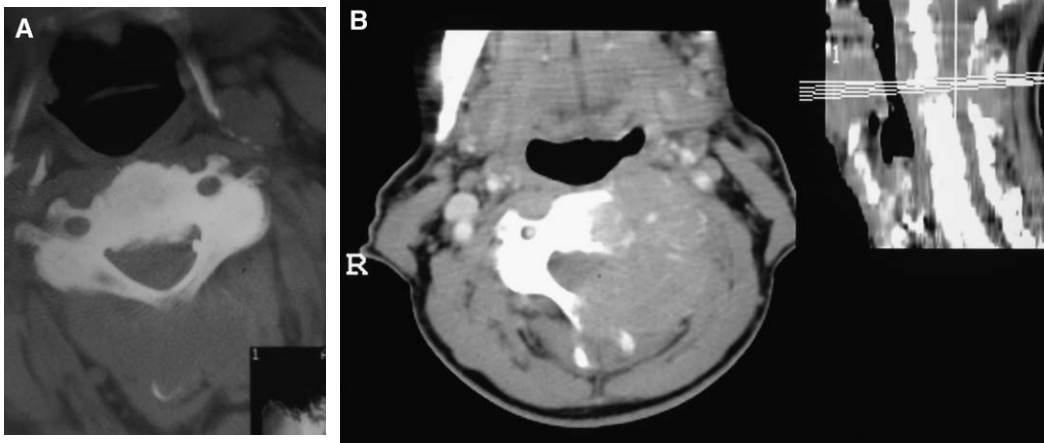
(A) CT scan showing extradural tumor destroying posterior spinous process. (B) CT scan showing extradural metastasis destroying the lateral aspect of a cervical vertebra.
